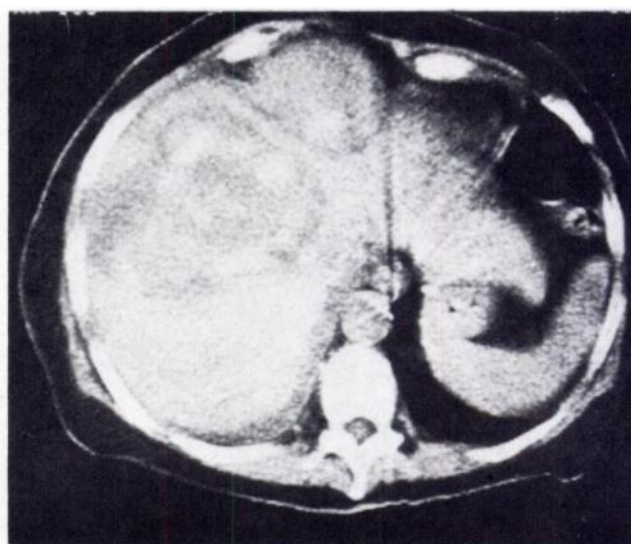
CT scan showing extent of hepatic damage caused by bullet that penetrated liver from thorax. Areas of increased density within large low density lesion probably blood. Somewhat localized mass anteriorly may be subcapsular collection. Patient recovered without surgical intervention.
